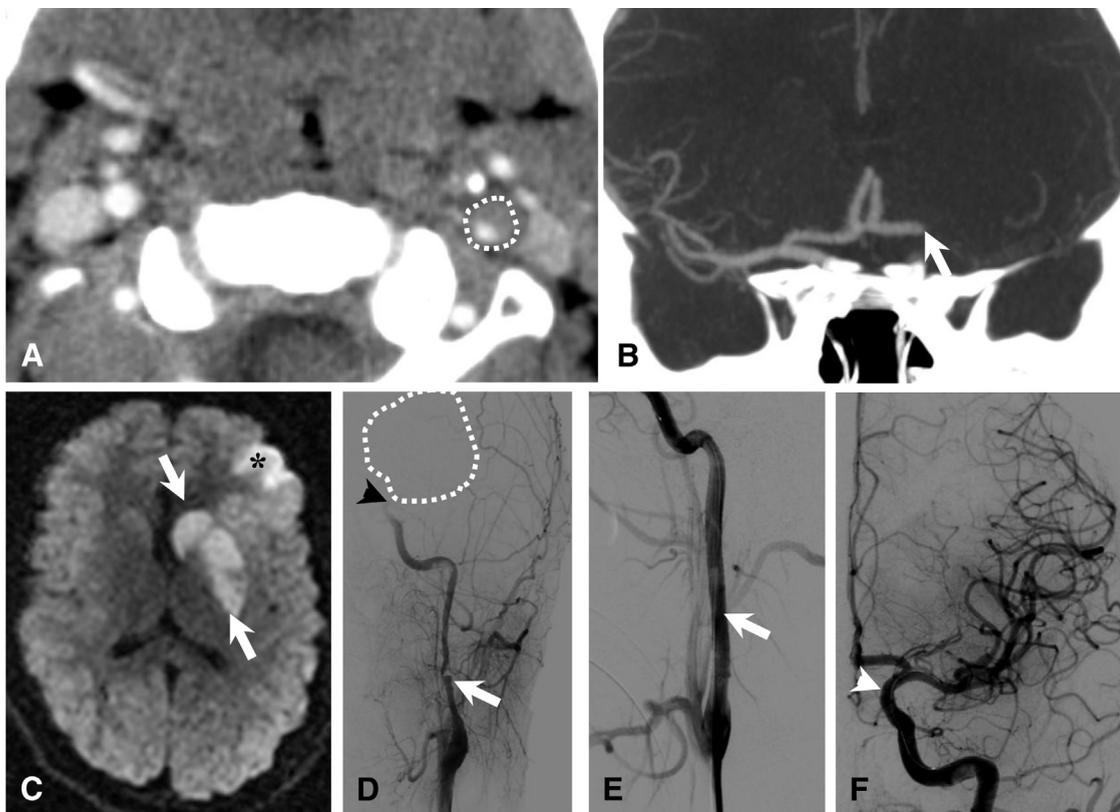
Case 2. Axial computed tomography (CT) angiogram of the neck (A), coronal maximum intensity projection reconstruction of CT angiogram of the brain (B), axial diffusion-weighted magnetic resonance image (DW-MRI) of the brain at the level of the basal ganglia (C), digital subtraction angiography (DSA) before (D) and after (E, F) endovascular treatment. The dotted circle in (A) delineates the contour of the cervical segment of the left internal carotid artery (ICA). Filiform contrast opacification of the carotid lumen (round-shape white content) secondary to the presence of dissection with a thrombosed false lumen (crescent-shaped dark content). The white arrow in (A) points the normal contralateral ICA. The arrow in (B) indicates complete occlusion of the intracranial segment of the left ICA. DW-MRI date shows restricted diffusion on the left basal ganglia (arrows in C) and left frontal lobe (*) consistent with an ischemic infarct. The DSA shows severe narrowing and irregularity of the cervical segment of the left ICA secondary to post-traumatic dissection (arrow in D), complete occlusion of the petrous segment of the left intracranial ICA (arrowhead in D), and absent blood flow distal to the obstruction (dotted circle in D). Blood flow restoration at the cervical (arrow in E) and intracranial (arrowhead in F) segments of the left ICA after stent placement and mechanic cloth retrieval. Note the intracranial blood flow restoration after the intravascular therapy of the occluded segment of the intracranial ICA (arrowheads in D and F).
